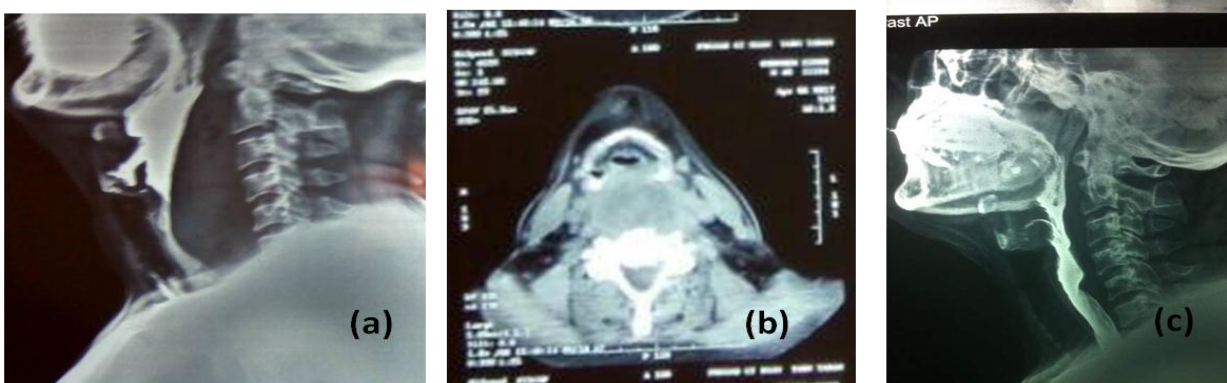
a) Barium swallows showing smooth esophageal wall; b) CT neck showing collection in retropharyngeal space; c) Postoperative barium swallow showing normal esophageal lining.
